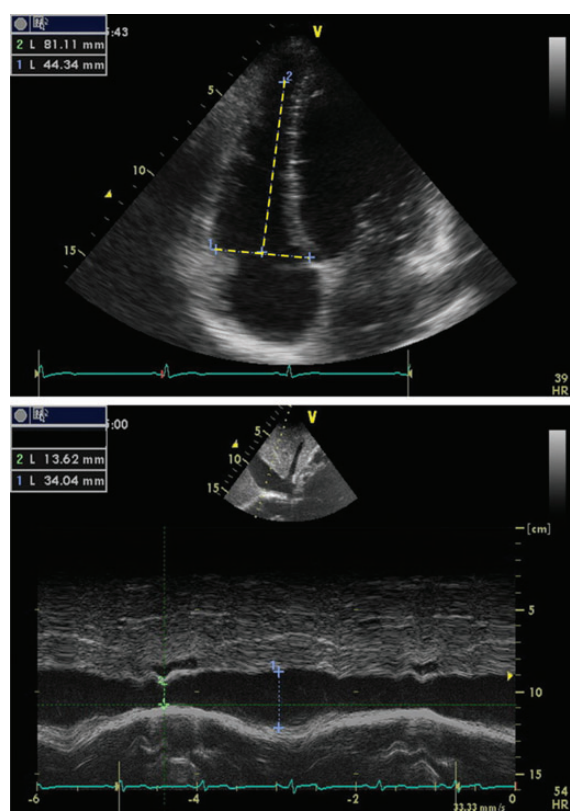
Right ventricular enlargement and inferior vena cava dilation in an endurance athlete. Upper panel: The apical four-chamber view shows increase of both RV basal diameter (1 = 33.34 mm) and of RV base-to-apex length diameter 2 = 81.11 mm). References normal values (RV basal diameter = 20–28 mm, RV base-to-apex length diameter = 71–79 mm) from Lang *et al.*⁸¹). Lower panel: M-mode recording inferior vena cava. 1 Maximal diameter = 34.04 mm, 2 minimal diameter = 13.62 mm. In athletes, inferior vena cava dilation is typically associated with extremely good respiratory reactivity.
